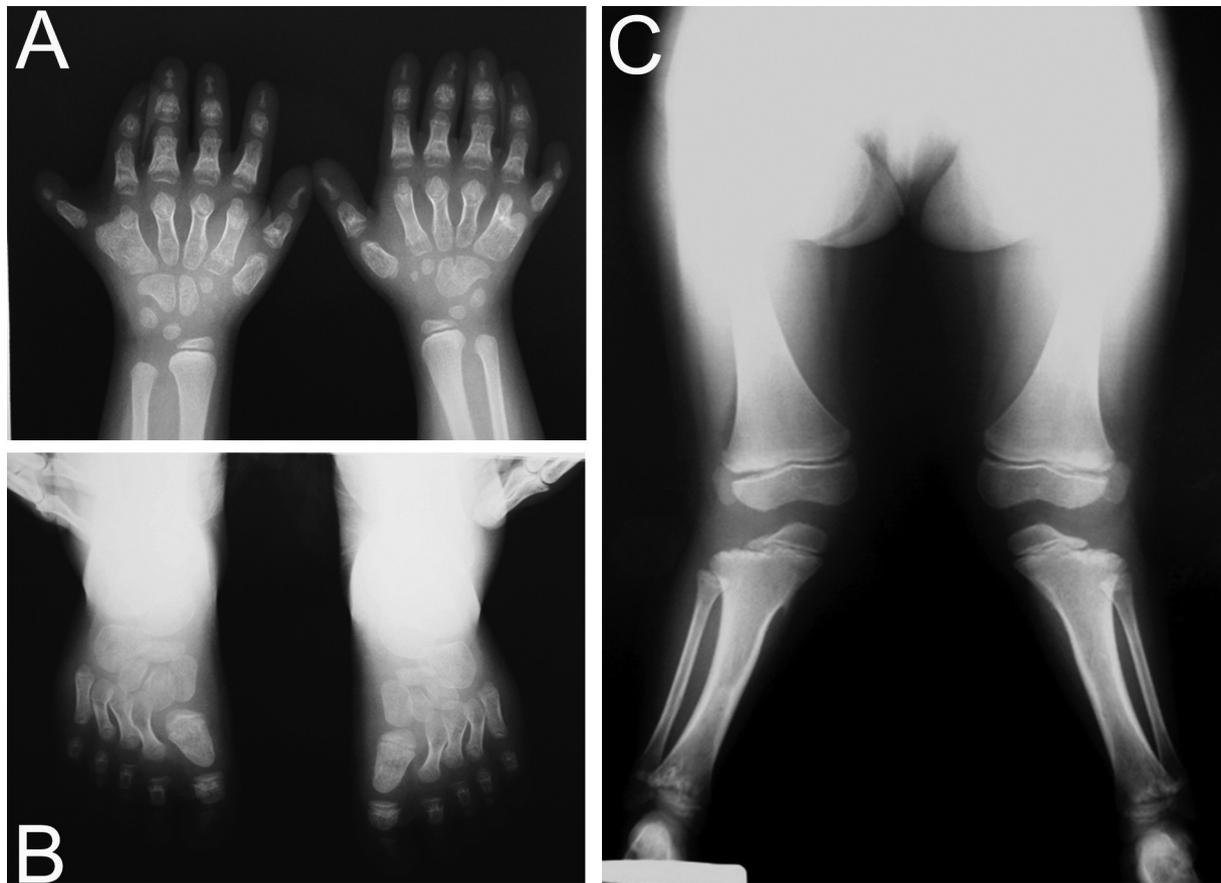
(A, B, C) Skeletal radiography revealed osseous syndactyly of the 5th and 6th metacarpals of the left hand, clinodactyly of the 6th finger, hypoplastic phalanges, metacarpals and metatarsals of the hands and feet, and disturbance in bone modeling of the tibial zone (distal extremity).
